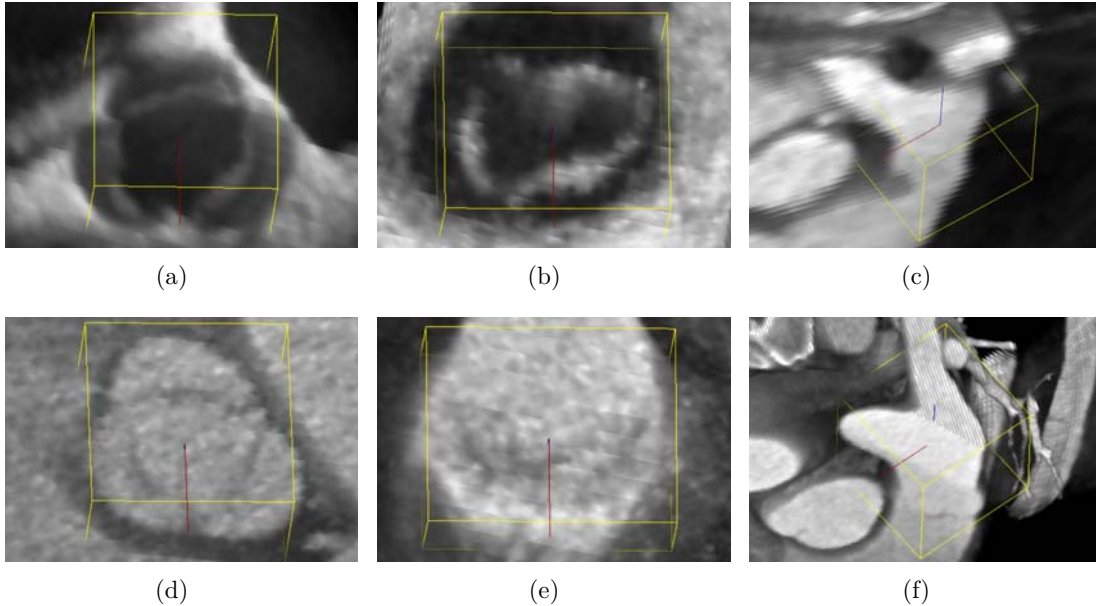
Examples of global location and rigid motion estimation: (a) aortic valve in TEE, (b) mitral valve in TEE, (c) pulmonary valve in CMR, (d) aortic valve in cardiac CT, (e) mitral valve in cardiac CT, and (f) pulmonary valve in cardiac CT.
